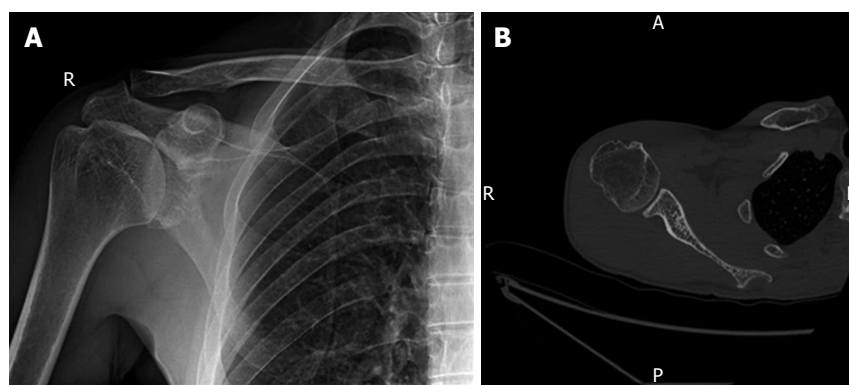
42-year-old manual worker with anterior shoulder instability with < 25% glenoid bone loss and an engaging Hill-Sachs lesion. He was managed successfully with an arthroscopic Remplissage and Bankart repair. Pre-operative antero-posterior radiographs (A) and computed tomography (B) images are demonstrated.
